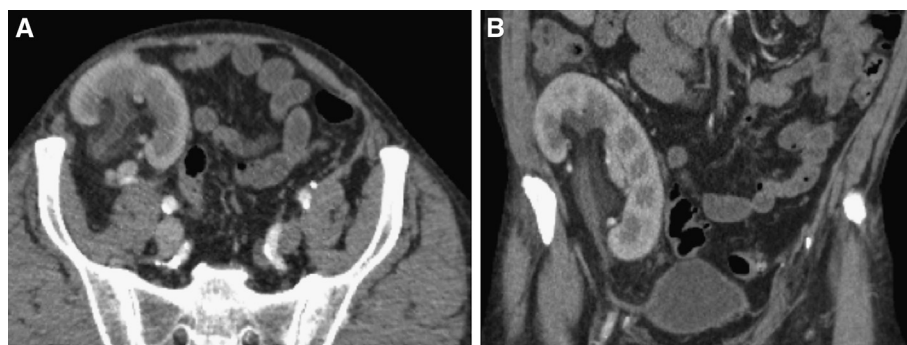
Axial (A) and coronal (B) sections from a contrast-enhanced (cortical nephrogram—phase) computed tomography of normal renal transplantation, showing intense cortical enhancement and mild stranding in the renal pelvis without hydronephrosis or perirenal fluid.
